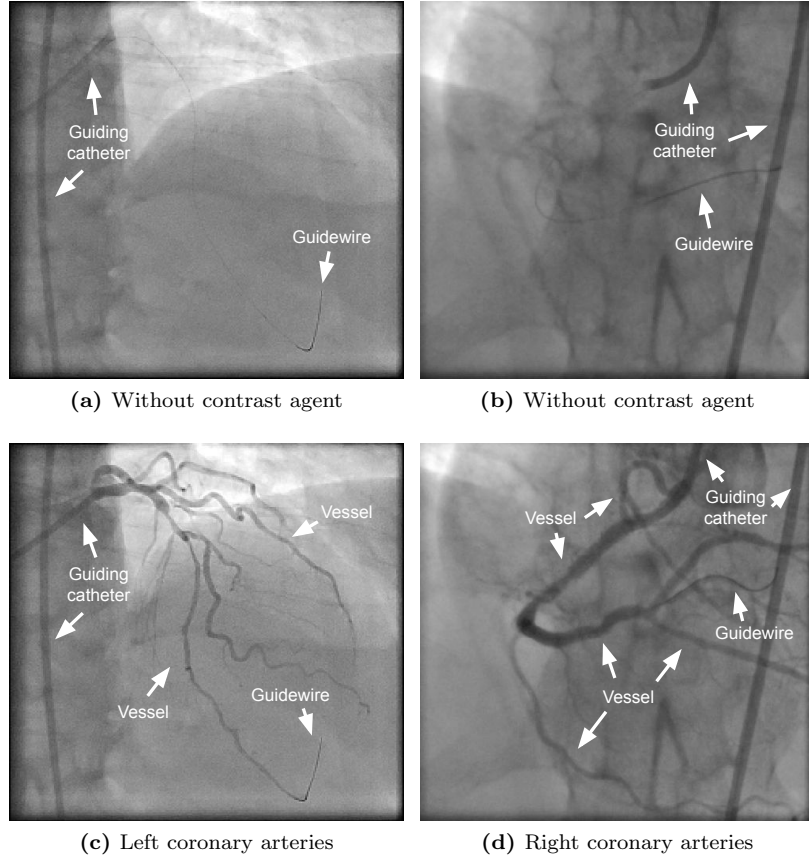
Examples of X-ray images for PCI. In (a) and (b), contrast agent has not been injected, guiding catheter (the long, dark, thin tube) and guidewire (the thin wire) can be seen in the images. In (c) and (d), contrast agent is used for visualizing the left (c) and the right (d) coronary arteries.
